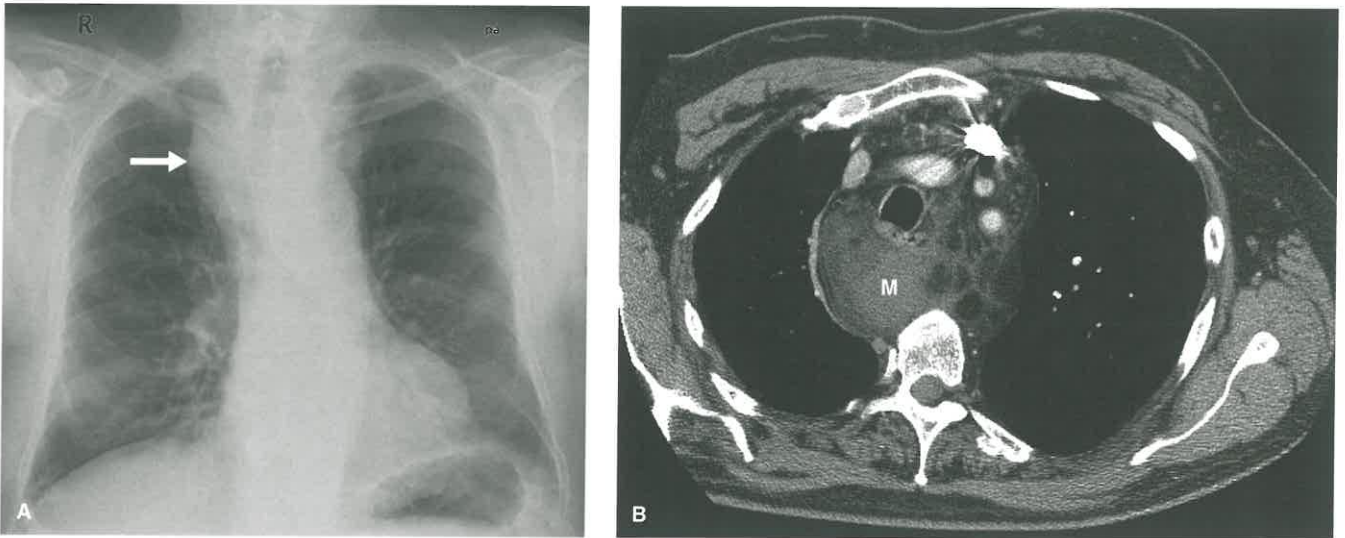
Liposarcoma of Mediastinum. A: Frontal chest radiograph in an 83-year old man with dysphagia shows a superior mediastinal mass (arrow). B: Contrast-enhanced axial CT shows a mixed attenuation mass (M) with fatty and soft tissue elements infiltrating the mediastinum. CT-guided biopsy showed a liposarcoma confirmed at surgery.
